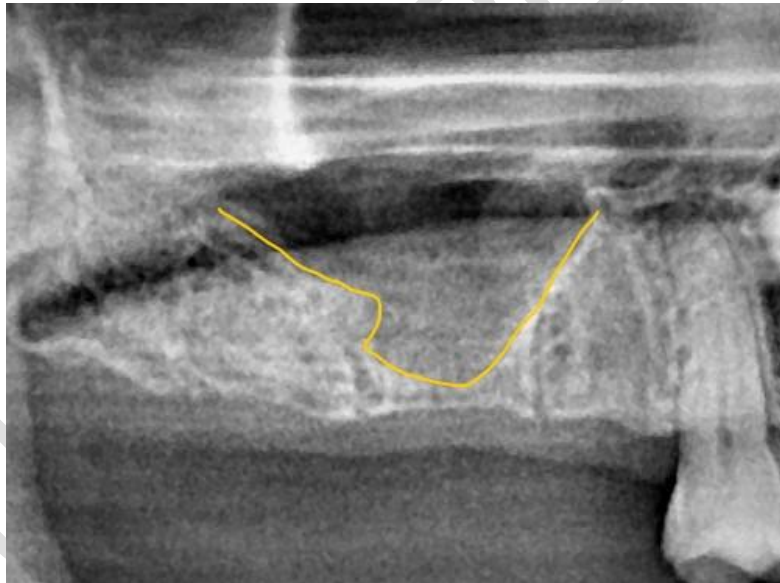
Preoperative radiograph showing pneumatisation of maxillary sinus in the region of #15, #16,#17
